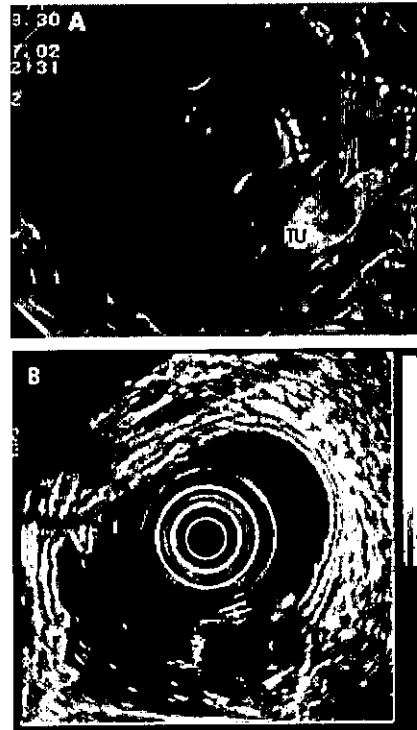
Submucosal tumour (TU) in the gastric body with endoscopic (A) and endosonographic (B) views.
